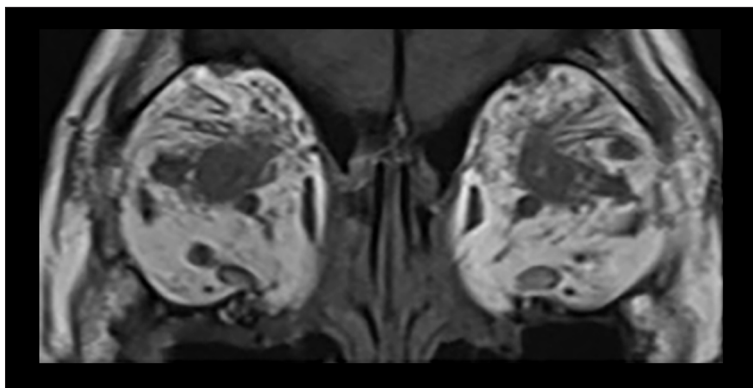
Coronal orbital magnetic resonance imaging findings (T1-weighted and fat-suppressed images using short-tau inversion recovery sequences); bilateral extraocular muscle enlargement with tendon sparing (TED) and diffuse orbital soft tissue / lacrimal gland infiltration with high STIR signal (IgG4-RD).
